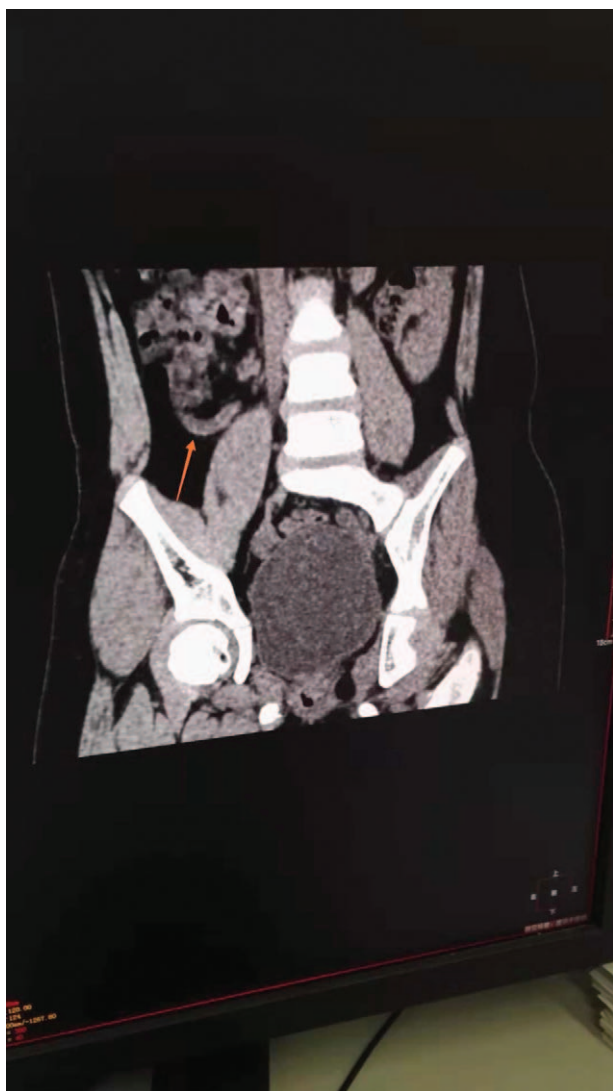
Abdominal computed tomography demonstrating enlarged appendix in diameter.
